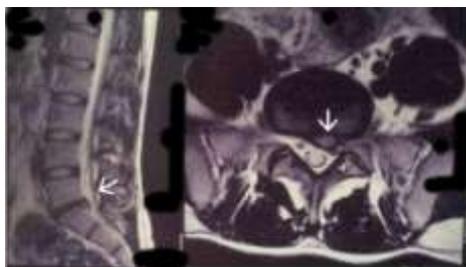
Sagittal and axial T2-weighted MRI of the lumbar spine images show an extruded disc fragment on the left side at the L5-S1 level.
